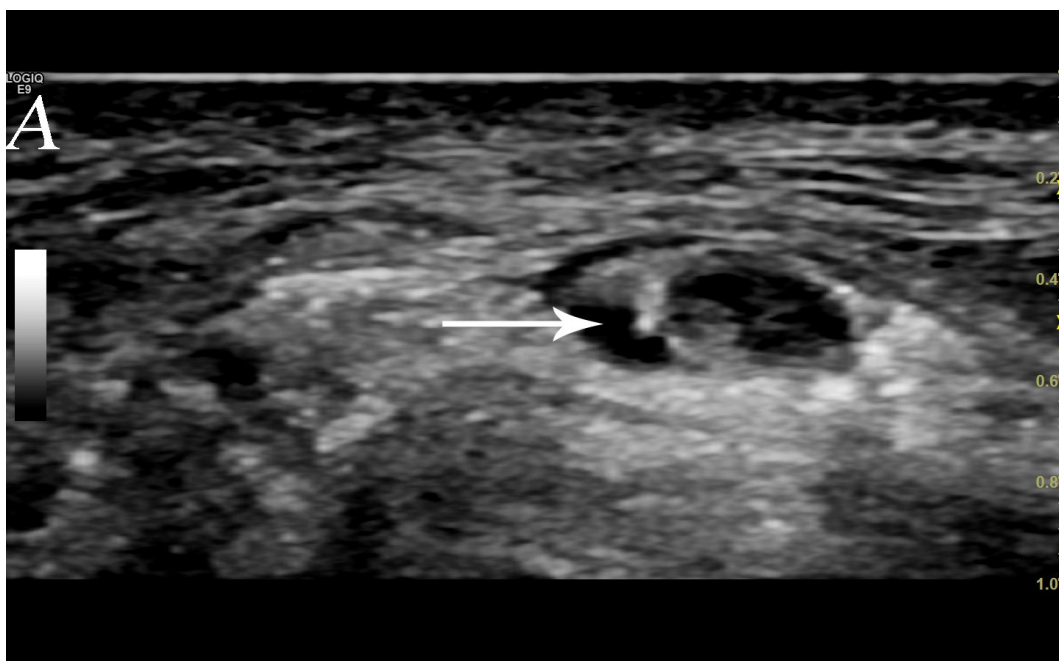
The ultrasound showed a normal appearance of the cysts, a hypoechoic around part of the ulnar nerve(A-C).The white arrow is cyst, the yellow arrow is ulnar nerve.
